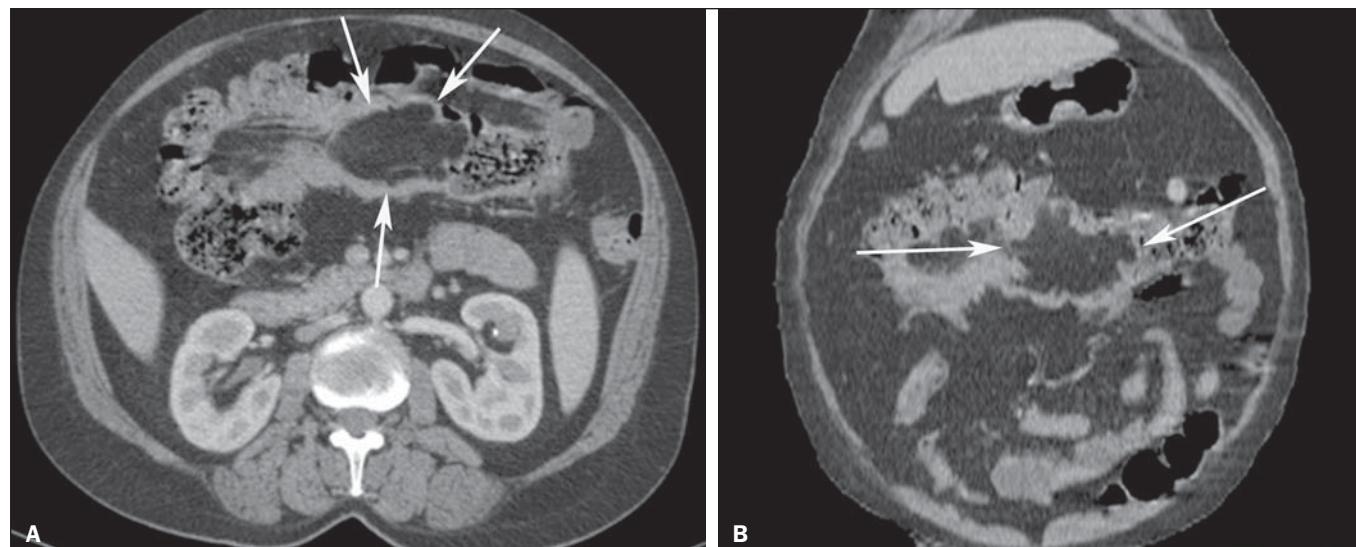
Axial CT section (A) and coronal reformation (B).
